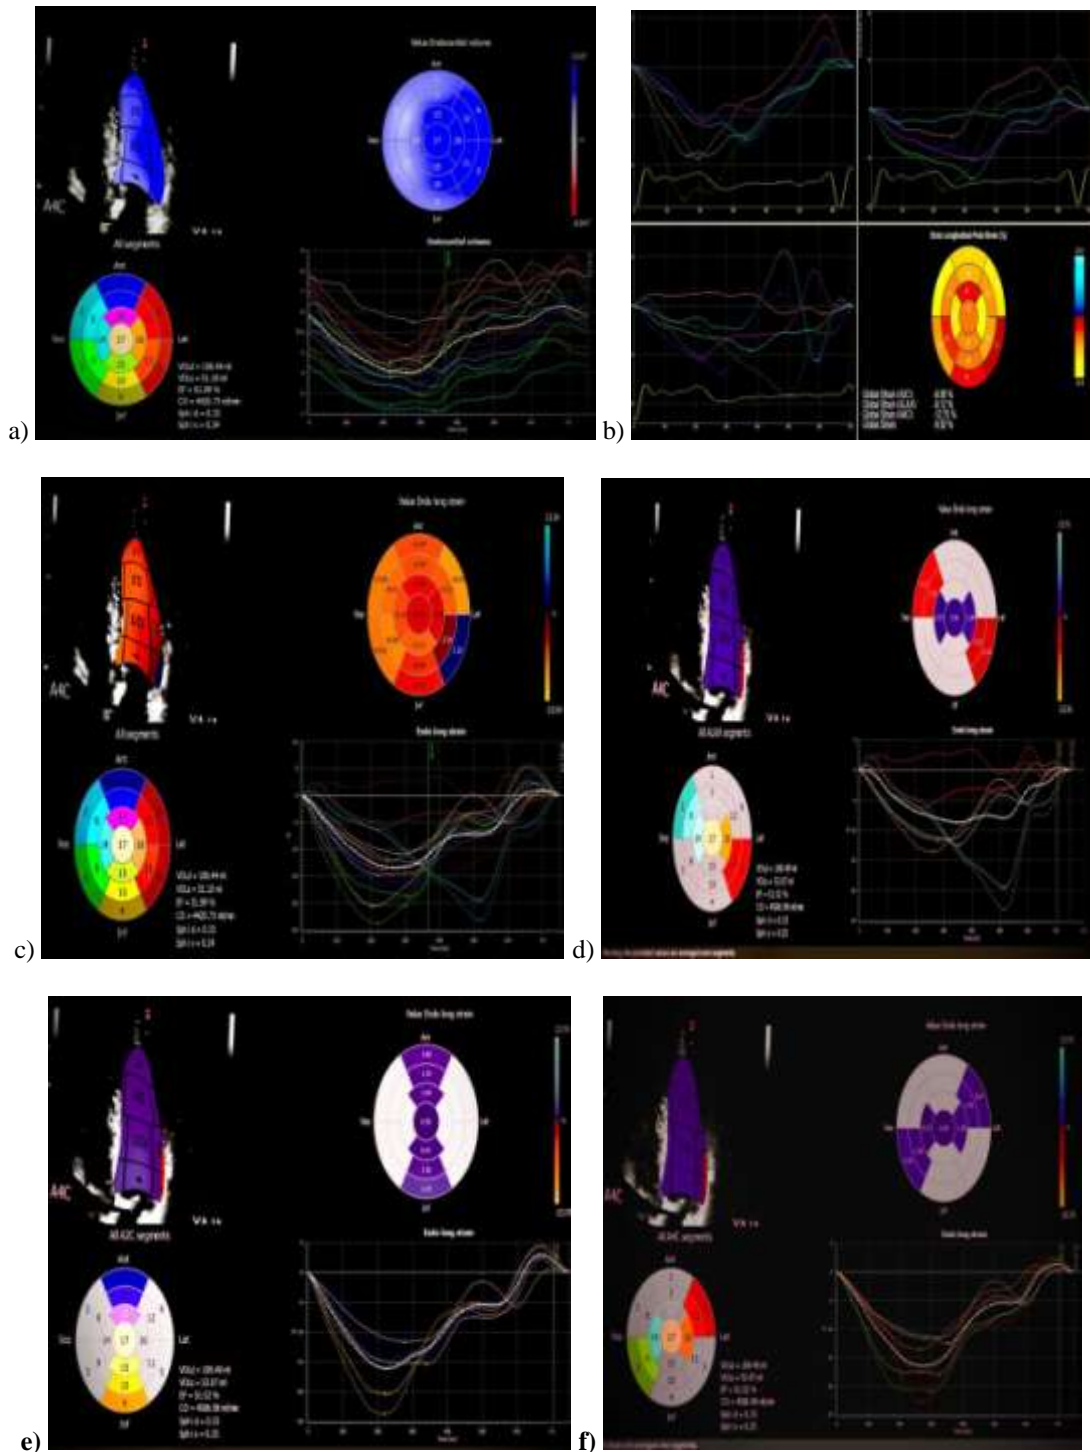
4Dimensional XStrain speckle tracking echocardiography-a) LV volumes, cardiac output, sphericity index and ejection fraction were normal- LVEF 51.99 %, b) “Bulls” eye representation of polar mapping of LV strain identified severely depressed values of LV strain - global LV strain, 2CH strain, LAX strain and 4CH strain were -9.92 %, -8.88 %, -8.12 % and -12.75 % respectively, c) polar mapping of strain of all the LV segments recognized marked depression of strain values in all the segments, particularly in the apical region , d- f) polar mapping of LV strain in LAX, 2 CH and 4CH view conspicuously revealed LV strain values ranging from - 0.54 to - 1.94 % in the apical segments.
